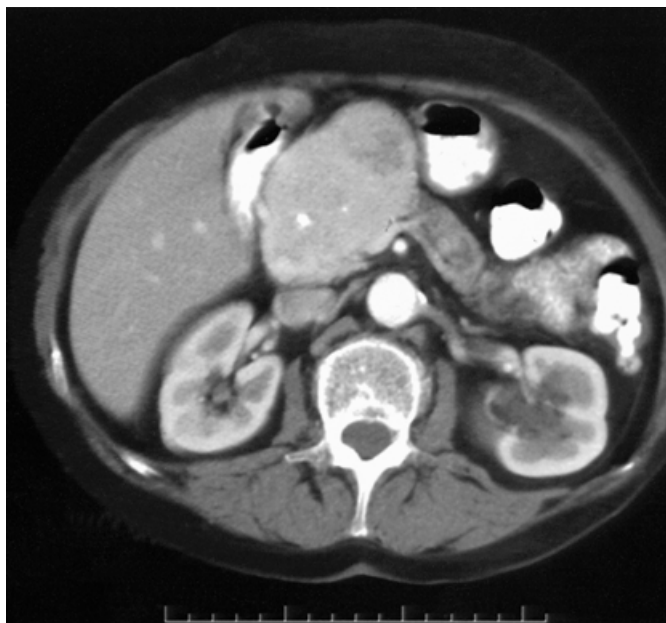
A 6 × 8-cm pancreatic head mass revealed by computed tomography scanning in an asymptomatic patient. This was a non-functioning pancreatic endocrine tumour producing pancreatic polypeptide at 1600 pg/mL (normal: 0–300 pg/mL).
